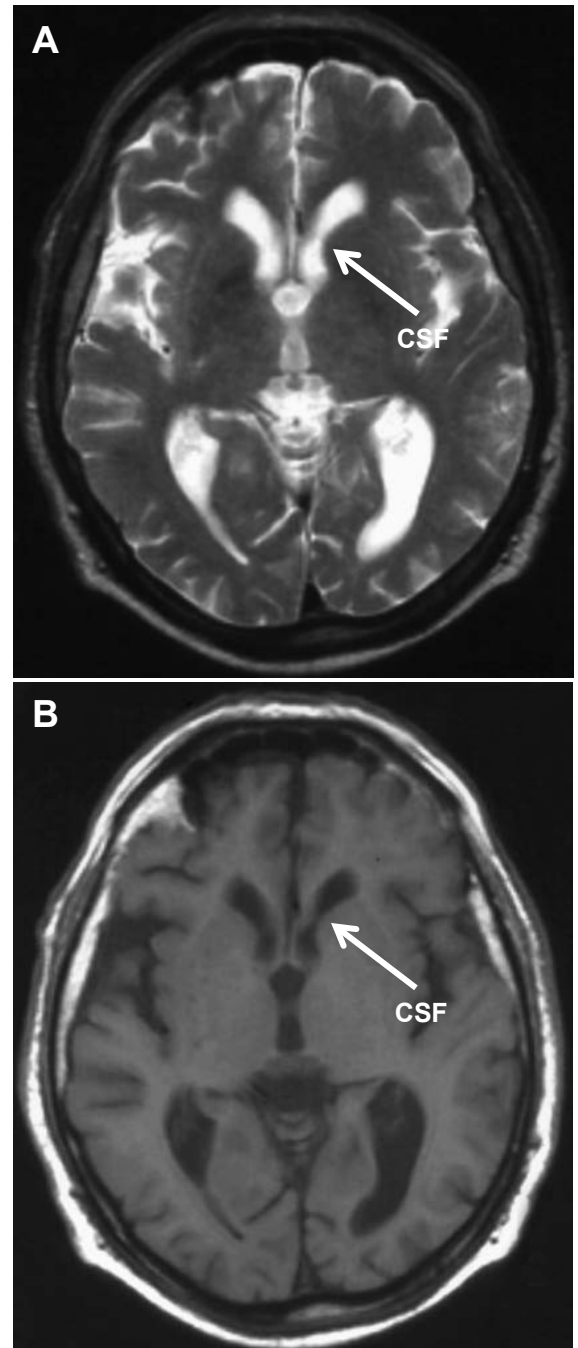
MRI of the brain. (A) Axial T2-weighted image. (B) Axial T1-weighted image at the same level. *Courtesy of Maimonides Medical Center, Brooklyn, NY.*
